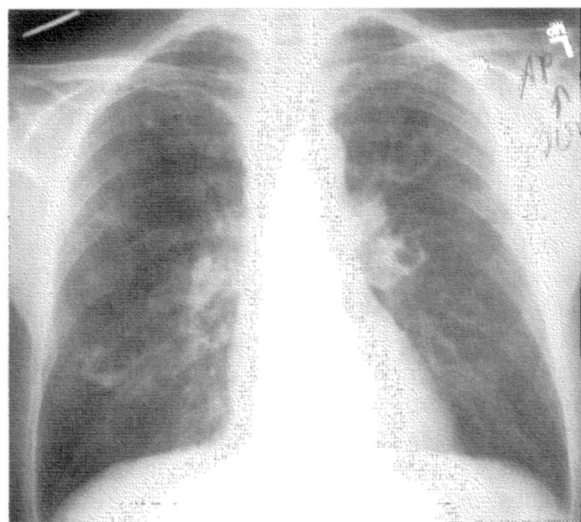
Chest (A) radiograph and (B) CT scan showing bilateral pulmonary cavitory lesions and lung abscesses.
